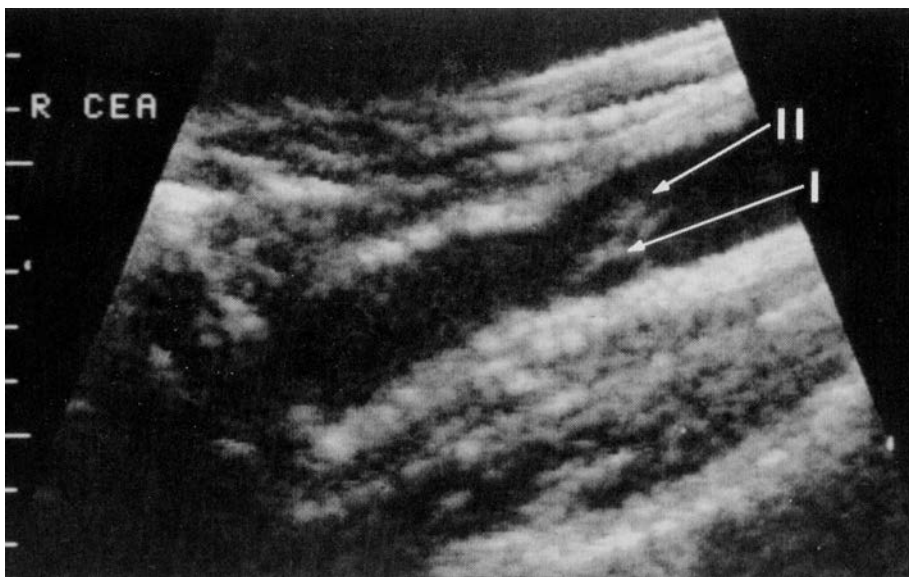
Intra-operative B-mode ultrasound demonstrating a residual plaque (I) and the associated platelet plug (II). Reprinted with permission from Kresowik TF, Hoballah JJ, Sharp WJ, et al. Intraoperative B-mode ultrasonography is a useful adjunct to peripheral arterial reconstruction. *Ann Vasc Surg.* 1993;7(1):33–38.
